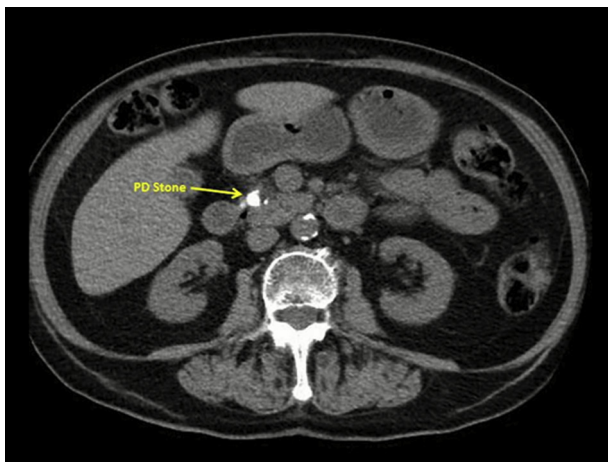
CT of the abdomen and pelvis revealed a large pancreatic duct stone.
